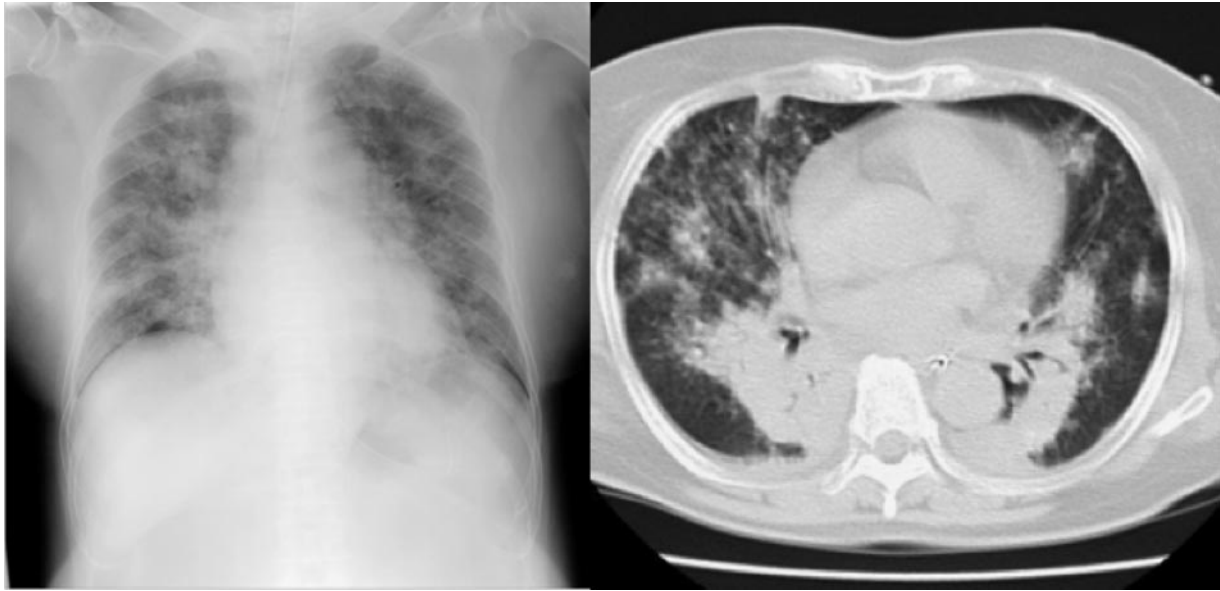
The chest radiograph (left) showing bilateral diffuse infiltration in all lung zones on admission. The computed tomography scan (right) showing moderate atelectasis in the bilateral inferior lobe.
